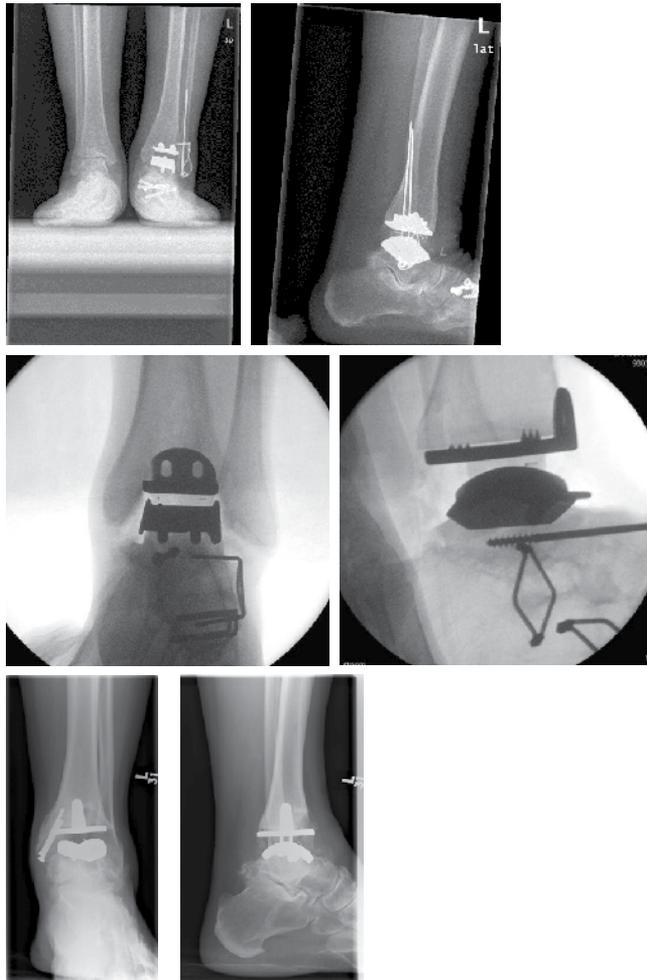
Radiographic images of three currently used mobile bearing total ankle arthroplasty designs. The top two images are STAR, middle two images are Hintegra and the bottom two images are Mobility.
